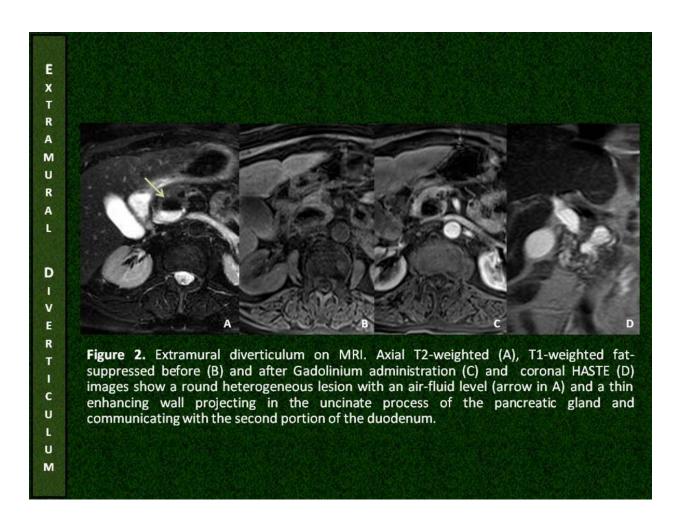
Extramural Diverticulum - MRI
